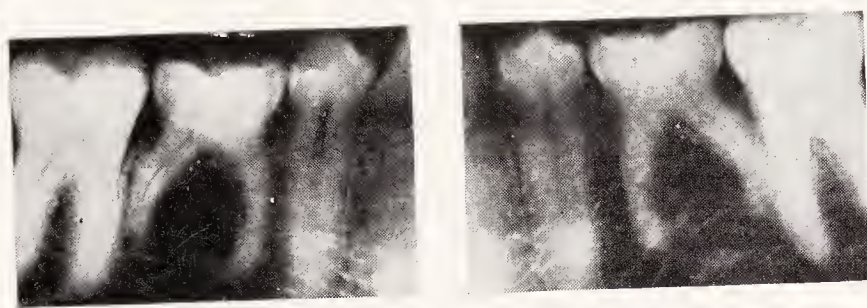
Radiographs of a patient, aged forty years, with retained lower deciduous molars. No second bicuspid are present. Notice the areas of resorption on the mesial roots of the deciduous molars. (Courtesy of G. E. Morgan.)
